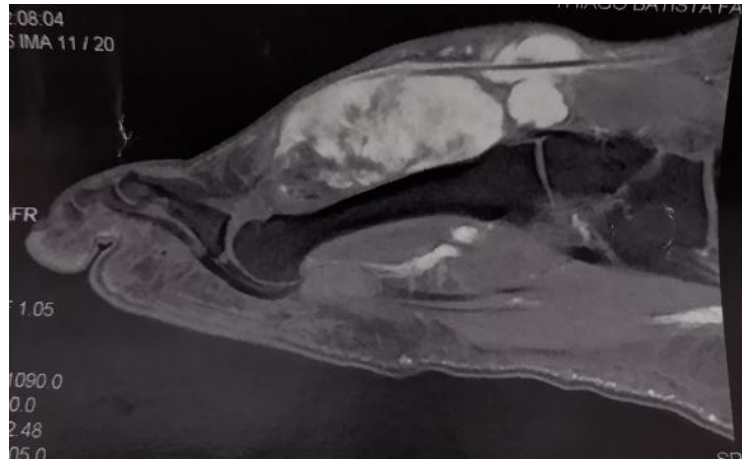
MRI of the- sagittal T2 sequence
